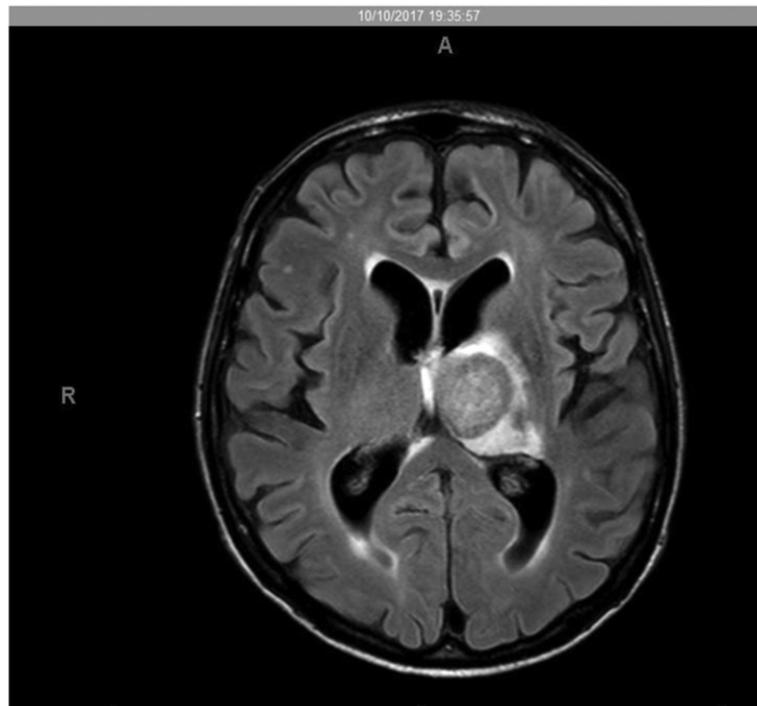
Brain CT scan showing a pseudotumoral lesion in a patient with the chronic form of the disease.
